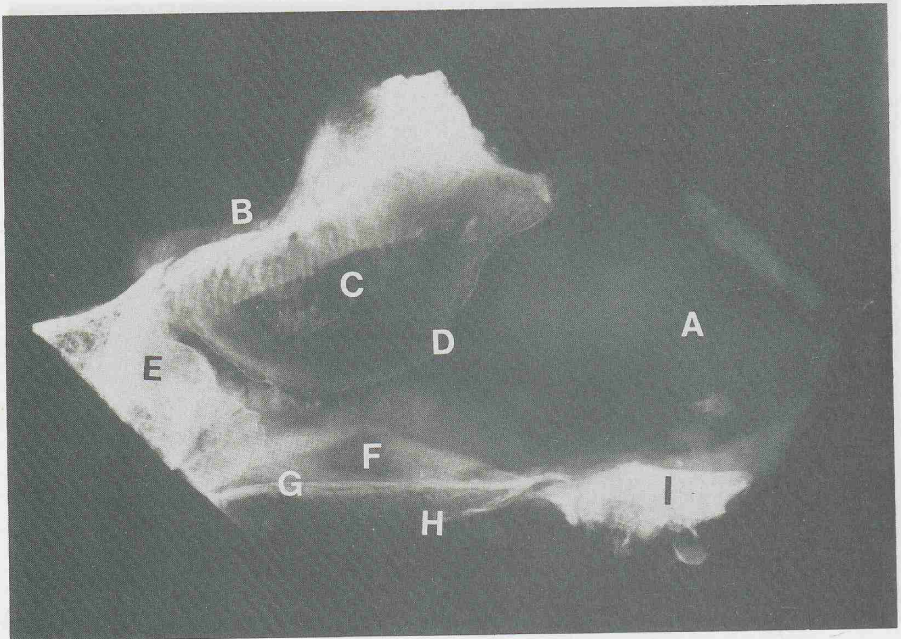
Lateral X-ray picture of nasal septum, age 10 years.
